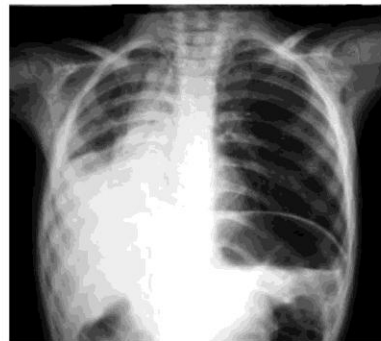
A chest radiograph of a 5 years old girl with persisting cough demonstrates left lung air trapping.
